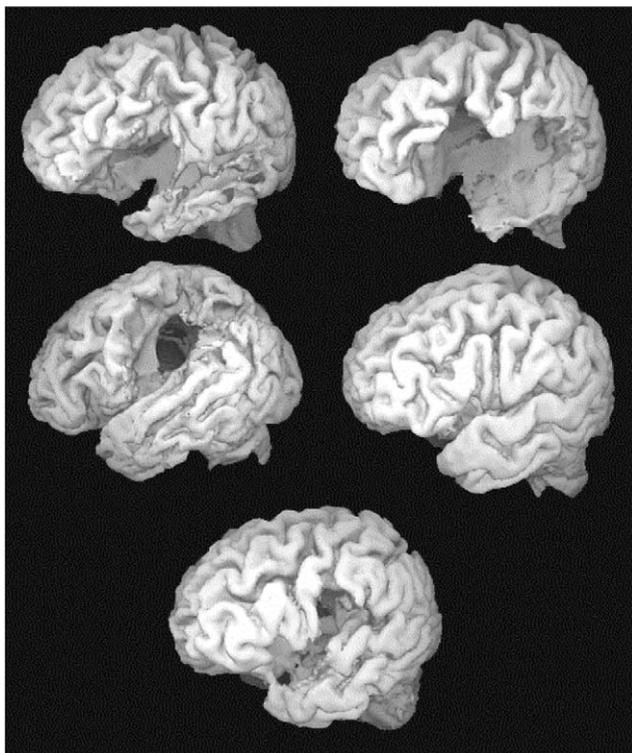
Localization of lesions in five stroke patients. Three-dimensional reconstruction of structural MRI studies from the five patients demonstrating the location of left hemispheric infarcts. In subject 4 the lesion was entirely subcortical.
